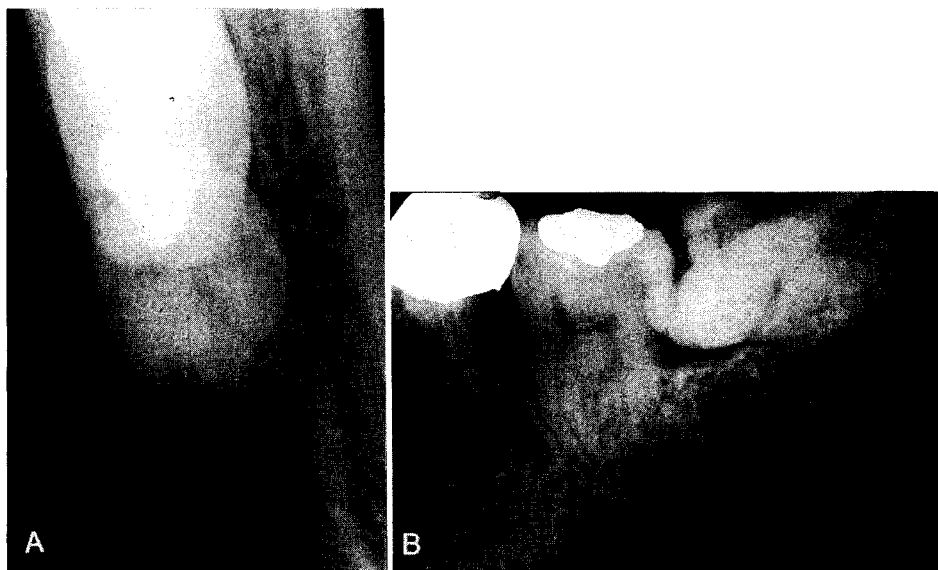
A, Radiographic image of bone loss seen in lingual cortical plate at lateral side of root of mandibular third molar in 37-year-old female. Note bone loss and thin cortex at concavity from mandibular body to ramus. B, Dental film of same subject shows degrees of impaction and angulation of third molar seen in many of the subjects.
